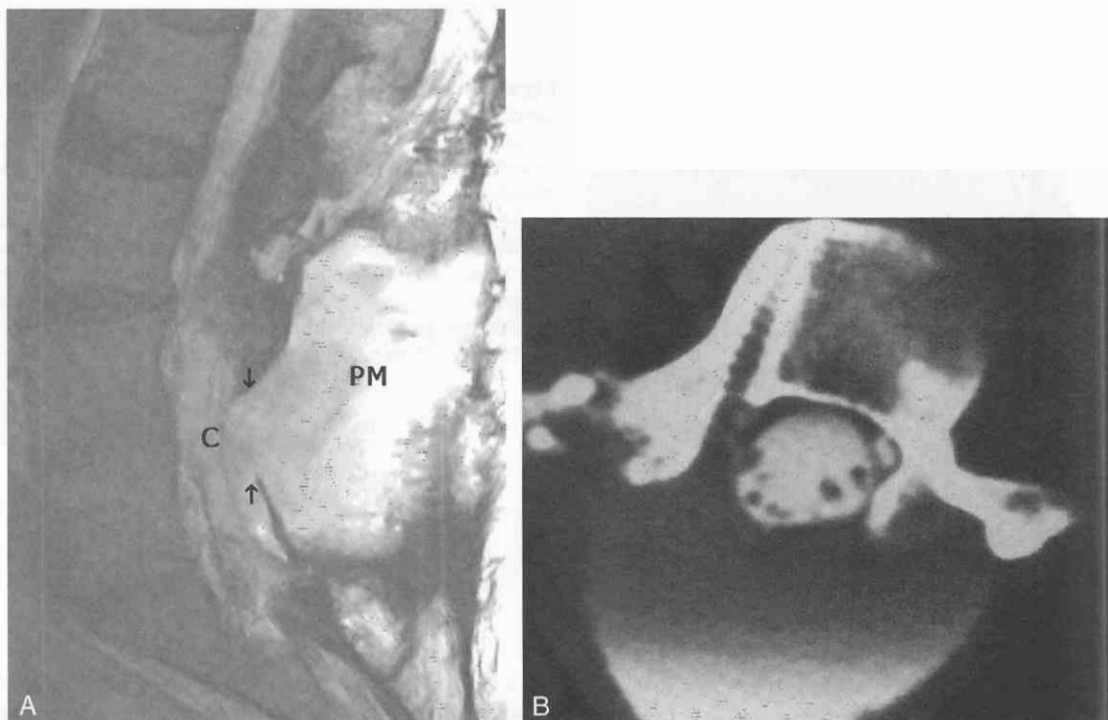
Pseudomeningocele. A, Postsurgical sagittal T2-weighted MRI shows large pseudomeningocele (PM). The communication (between the arrows) between the pseudomeningocele and the canal (C) is quite large. Compare with small, normal postoperative fluid collection shown in Figure 22-27, B, Axial postoperative CT scan in a different patient shows a large amount of intrathecally injected contrast pooling in a pseudomeningocele. Demonstrating the actual connection between the pseudomeningocele and the thecal sac can be difficult at times and could not be shown in this figure.
